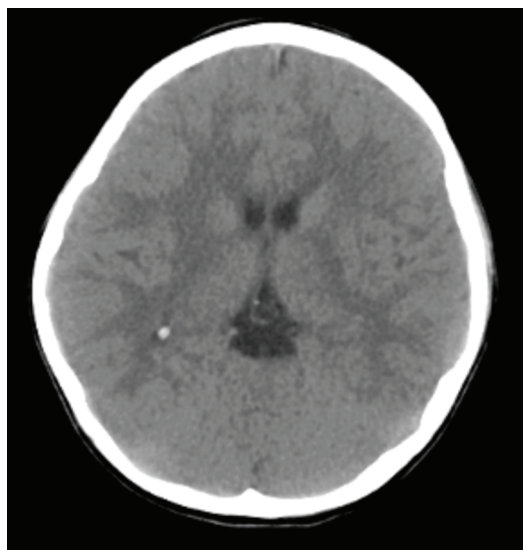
Pineal Cyst: Axial cranial CT image shows small (<1cm), round shape, isodense pineal gland cyst with milimetric cyst wall calcification
